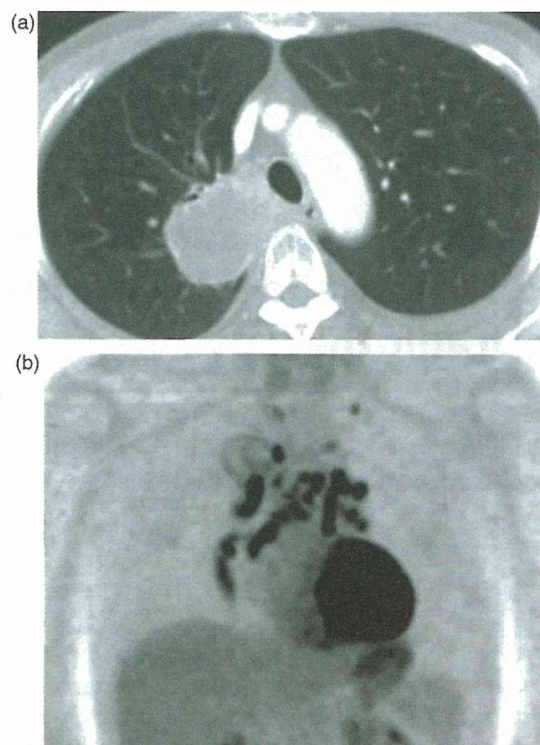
(a) Computed tomography scan showing a mass lesion measuring 55 mm in diameter in the right upper lobe and a single hilar lymphadenopathy. (b) Positron-emission tomography showing  $^{18}\text{F}$ -fluorodeoxyglucose accumulation in the lung tumor and one hilar lymph node.
